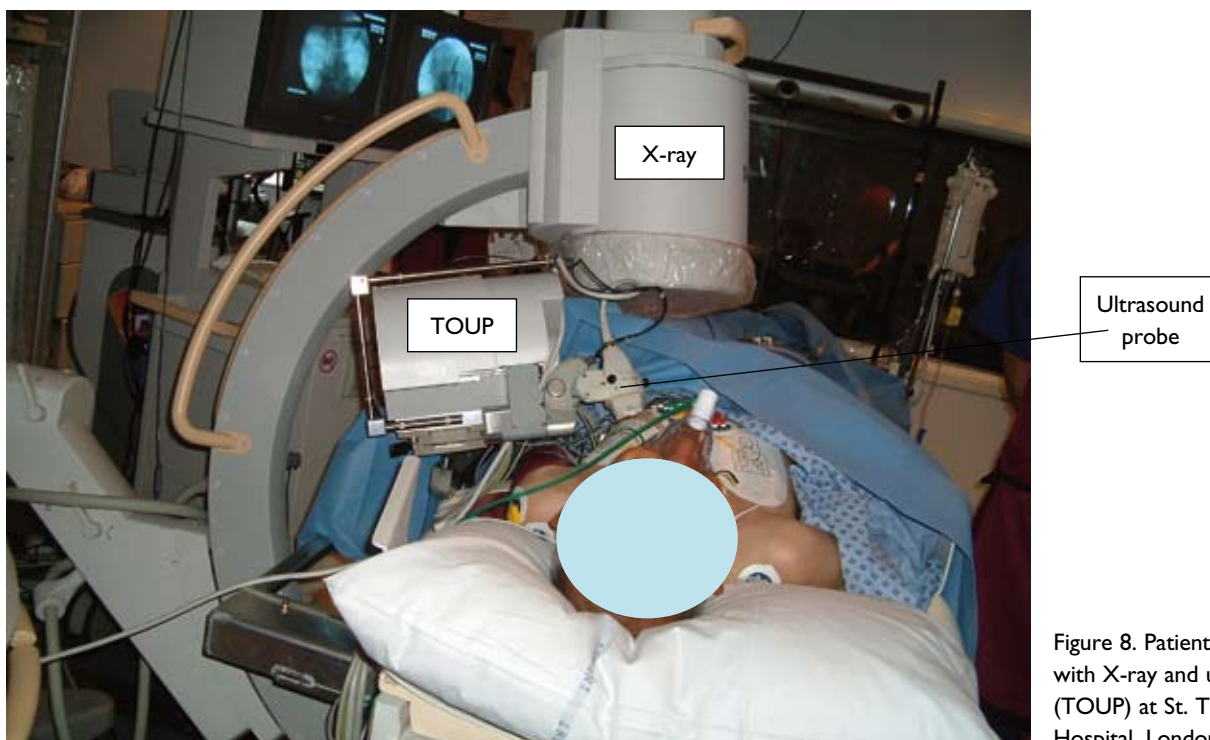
Patient study with X-ray and ultrasound (TOUP) at St. Thomas' Hospital, London.
